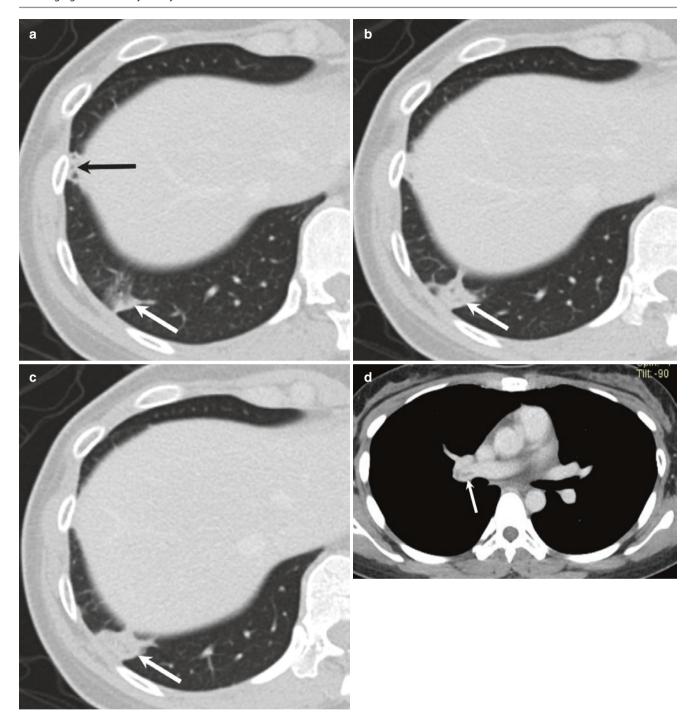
Typical appearance of pulmonary infarct in a 37-year-old woman with nonspecific chest pain who underwent a regular contrast-enhanced CT thorax. (a–c) Axial CT images with lung window settings show two peripherally located wedge-shaped consolidations
